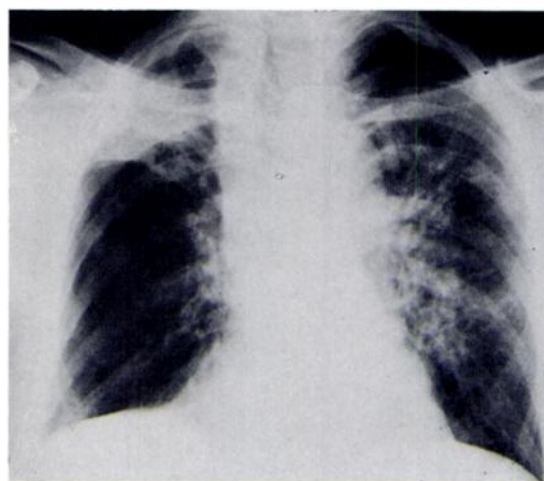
PA chest. Same patient as in Figure 8, 5 months later. Involvement of additional parts of the lungs in patient with recurrent aspiration. The chest roentgenogram cleared completely on a combination of antibiotics and steroids, following a hiatal hernia repair.
